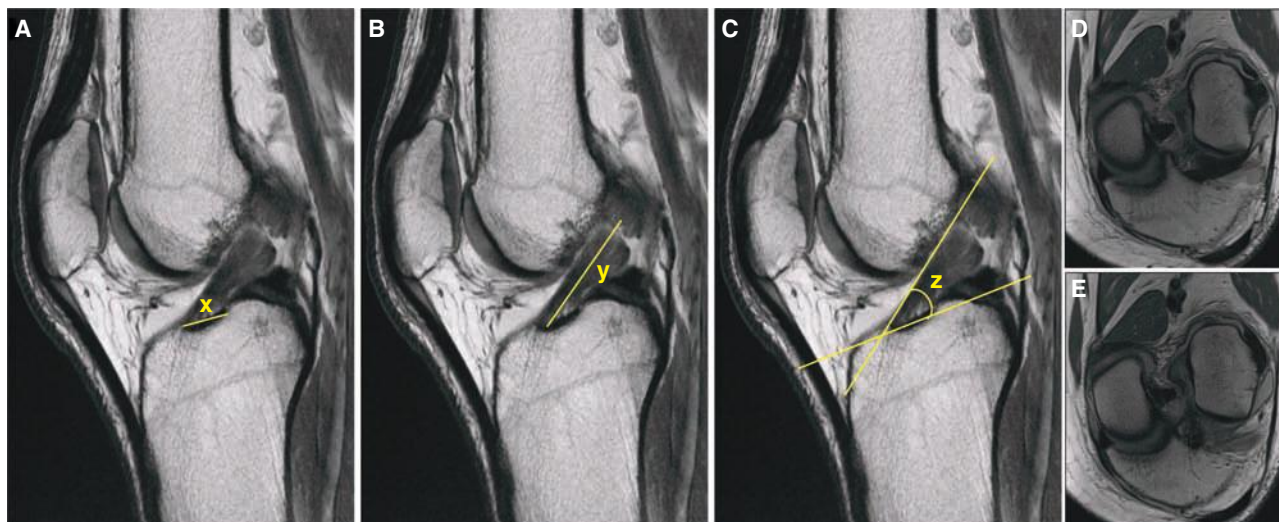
MR imaging of a torn ACL. (A-C) Proton density sagittal cuts; showing anteroposterior tibial insertion site length measurement “x”, intra-articular ligament length measurement “y” and ACL inclination angle measurement “z”. Oblique (in the same plane as the ACL runs) coronal cuts showing a complete ACL tear with separate images of a PL bundle tear (D) and an AM bundle tear (E).
